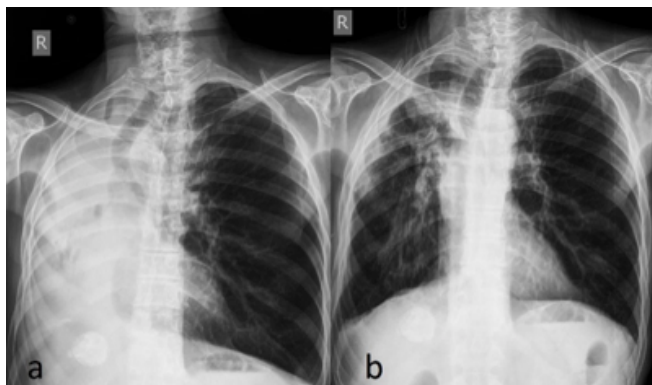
Chest X-ray showing the total atelectasis of the right lung due to main bronchus obstruction (a), the postoperative chest X-ray showed the lungs ventilated bilaterally (b).
